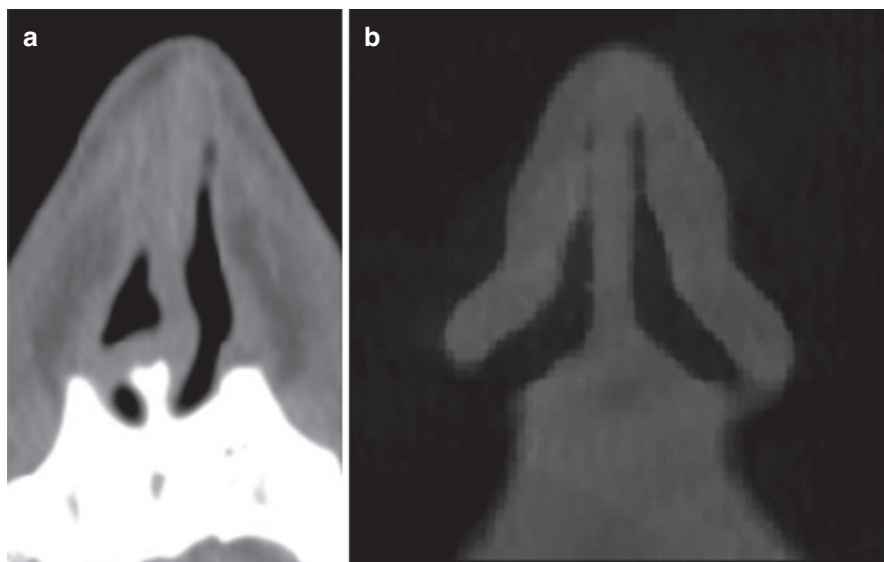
Coronal oblique cross sections of CBCT demonstrate the presentation of the collapsed internal nasal valve. (a) Collapsed nasal valves post-rhinoplasty. (b) The collapsed right nasal valve due to trauma
